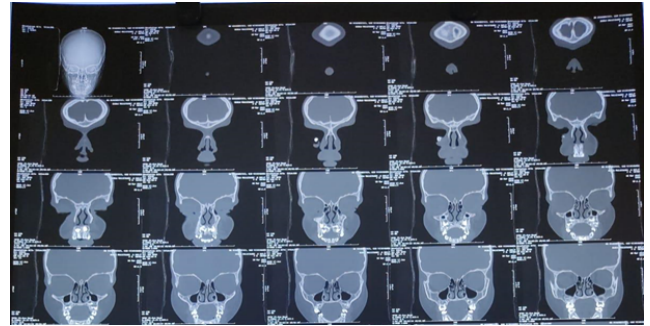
CT the radiopaque mass within the soft tissue. Maxillary sinus air density is radiolucent
